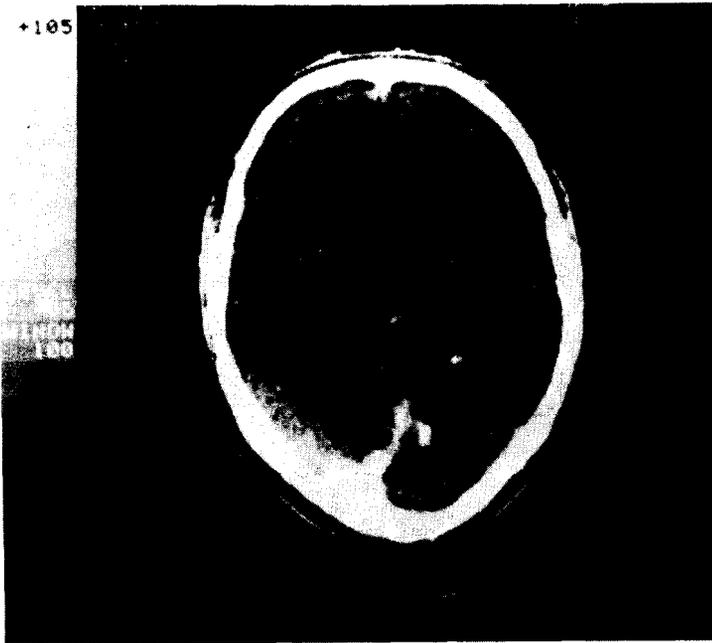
Patient 1: CT with contrast enhancement. Left occipital calcification.
